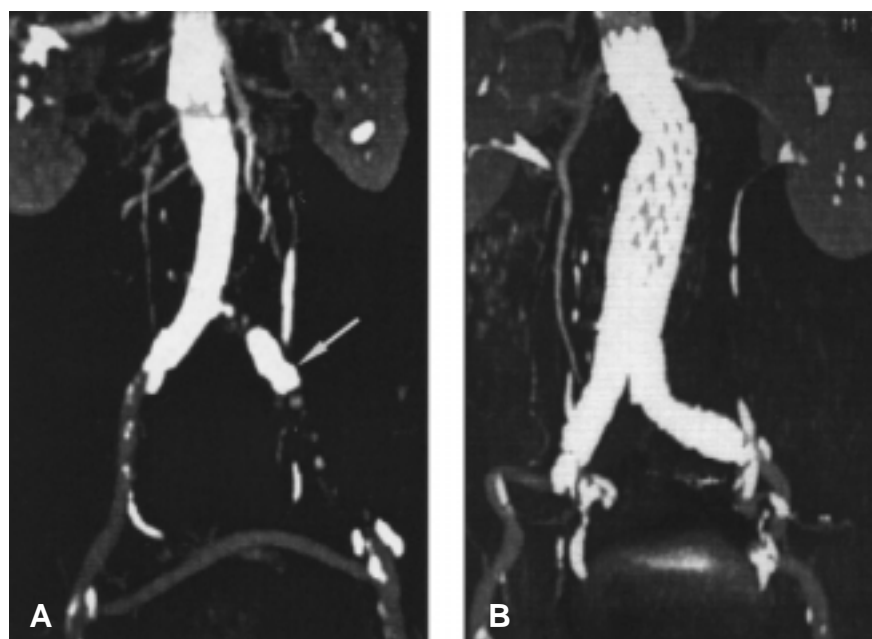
A, Maximum intensity projection of spiral computed tomographic scan that shows tapered aortomonoiliac stent graft, femorofemoral graft, and left common iliac occluder (arrow). B, Maximum intensity projection of spiral computed tomographic scan that shows bifurcated aortobiiliac stent graft.
